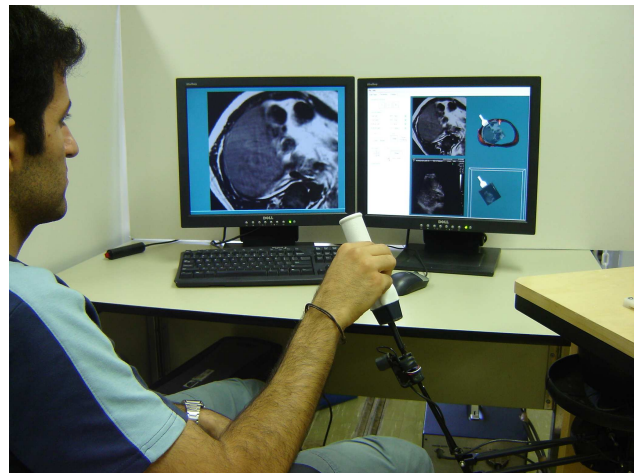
Picture of the haptic-based ultrasound training/examination system.
